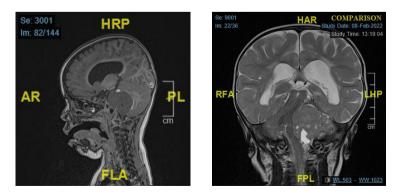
Left: MRI brain with contrast lateral view; Right: MRI brain with contrast sagittal view.
